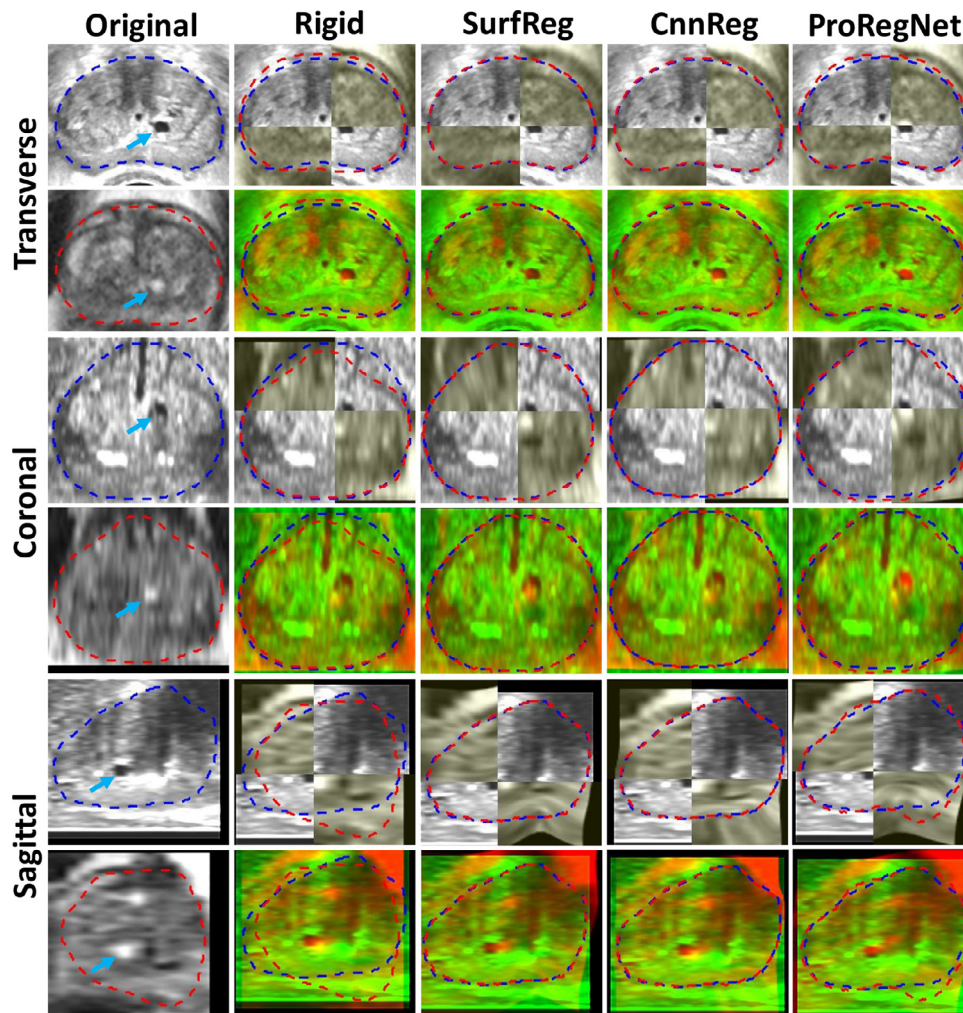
Example image slices from another case. Results are shown in the transverse, coronal and sagittal planes. First column shows the original TRUS and MR images. Second column shows the images after rigid registration in checkerboard and red-green fusion. Third, fourth and fifth columns show the registration results for SurfReg, CnnReg and ProRegNet, respectively. Blue dashed contour indicates the TRUS prostate shape while red dashed contour indicates MR prostate shape. The cyst within prostate were highlighted by arrows on the original images.
